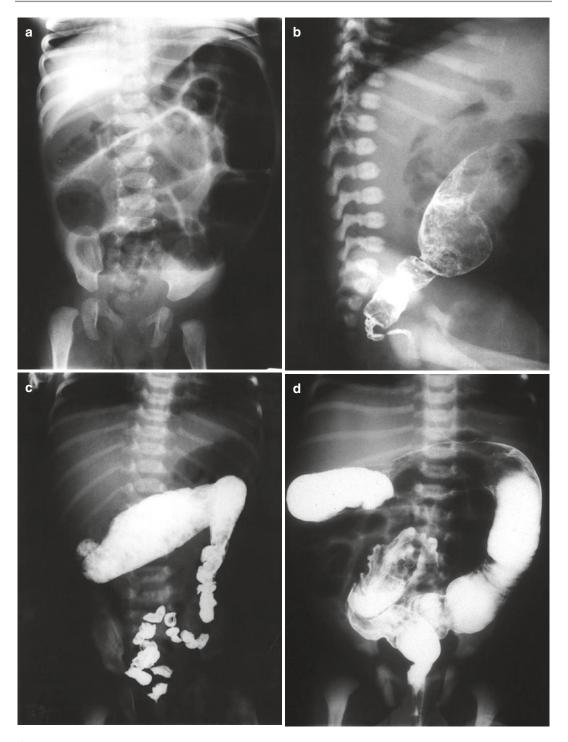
Radiological evaluations for Hirschsprung's disease: Plain abdominal X-ray film in a 4-day-old newborn showing marked dilatation of large and small bowel loops with gas in the undilated rectum (a). A barium enema in this patient revealed the transition zone at the recto-sigmoid level (b). Delayed 24-h film
